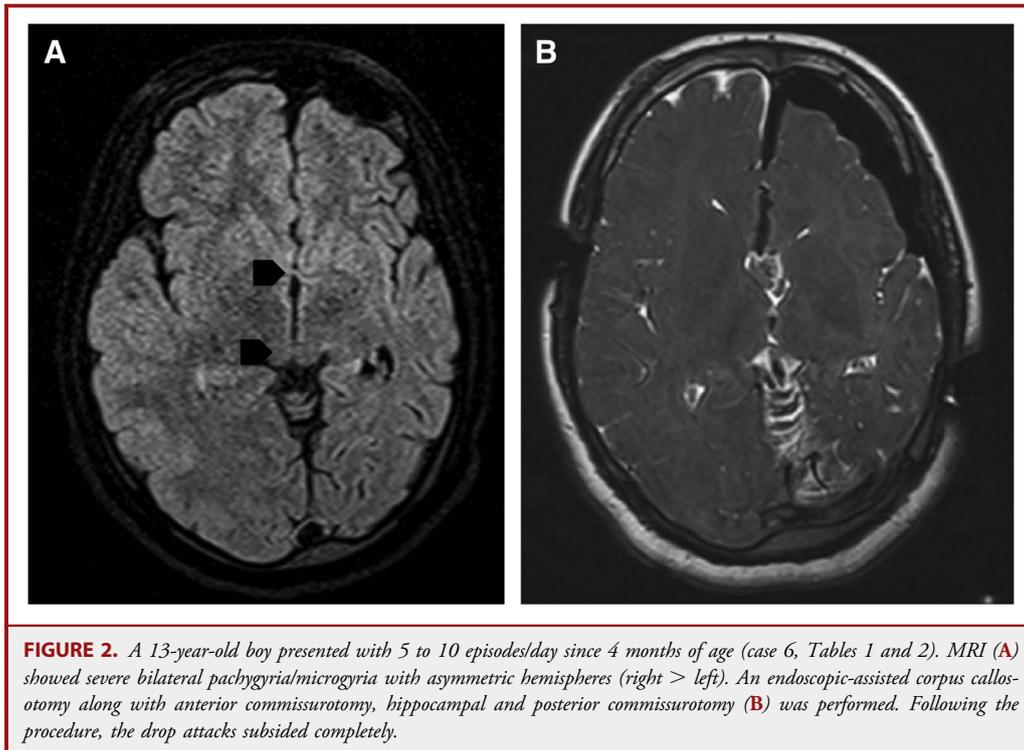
A 13-year-old boy presented with 5 to 10 episodes/day since 4 months of age (case 6, Tables 1 and 2). MRI (A) showed severe bilateral pachygyria/microgyria with asymmetric hemispheres (right > left). An endoscopic-assisted corpus callosotomy along with anterior commissurotomy, hippocampal and posterior commissurotomy (B) was performed. Following the procedure, the drop attacks subsided completely.
